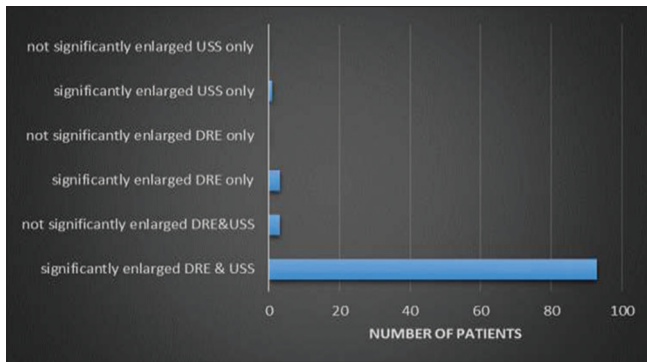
Bars depicting correlation between ultrasound and digital rectal examination
